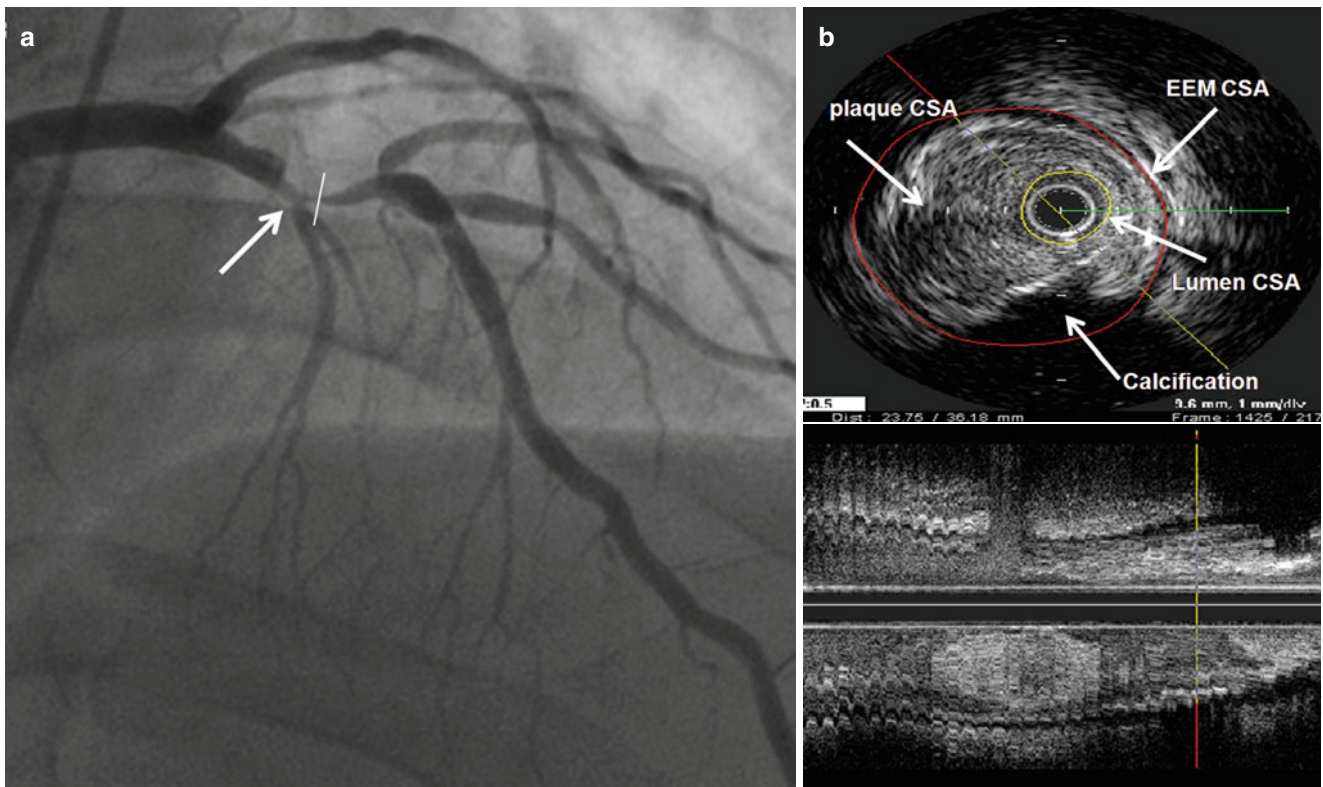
Invasive coronary angiography and intravascular ultrasound (IVUS) of the left anterior descending artery (LAD). (a) Invasive angiogram shows significant coronary artery stenosis in the proximal segment of LAD (arrow). (b) Cross-sectional image of IVUS on the level of white line on image a. IVUS demonstrates
